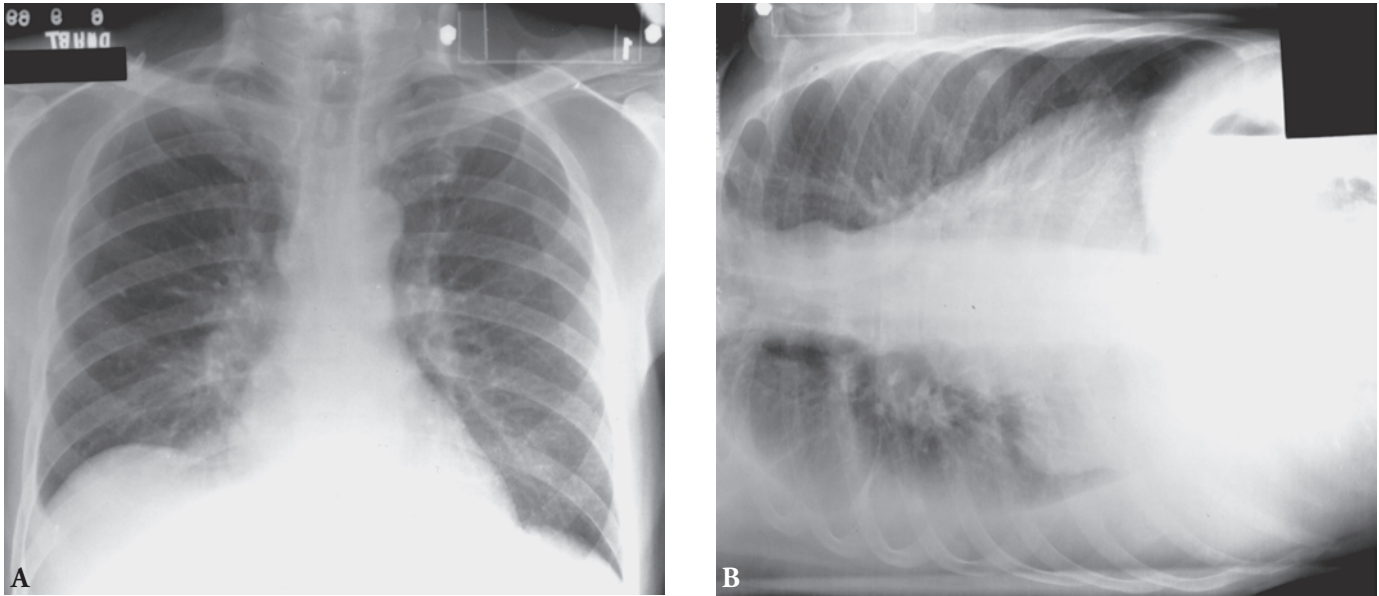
A*, PA CXR and, *B*, decubitus CXR. *A*, “Elevated right hemidiaphragm” that is really an intrapulmonic effusion, or subpulmonic, as seen on the decubitus film. *B*, For unknown reasons, a meniscus is not formed in some people with intrapulmonic pleural effusion. Thus, any seemingly elevated hemidiaphragm should be examined with the suspicion that it could be an intrapulmonic effusion. Subpulmonic effusions occur more frequently in patients with nephrotic syndrome. Decubitus CXR or ultrasonography would disclose the free fluid.
